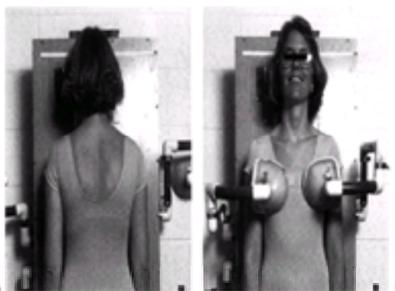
A: Positioning of a patient for a posteroanterior radiograph. B: Positioning of a patient for an anteroposterior radiograph with breast shielding.
